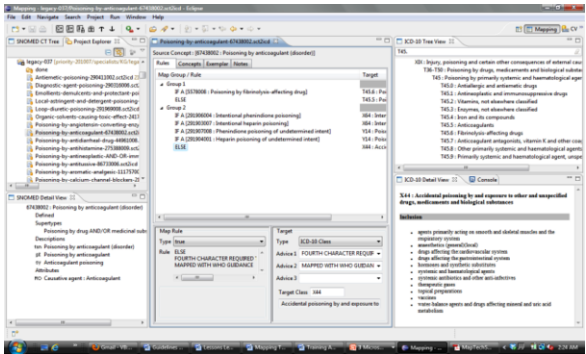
SNOMED CT to ICD-10 Mapping Tool Screen Shot
